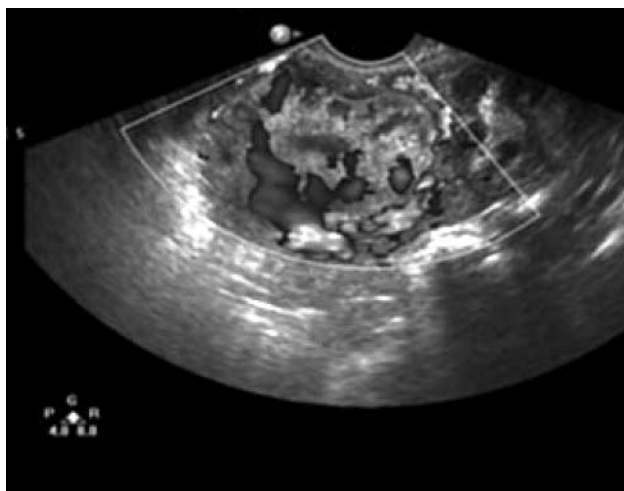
Typical CSP transvaginal color Doppler sonography, with rich flow signal seen in mixed mass.
